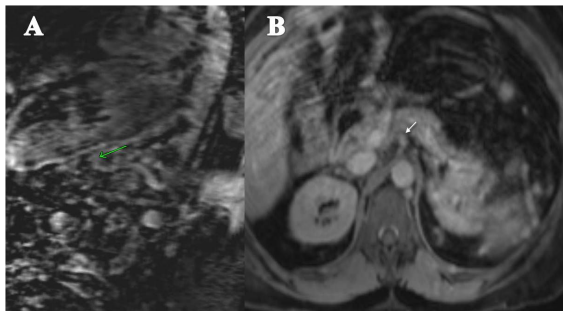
MRI & MRA reveal occlusion of the hepatic artery 2 cm from its origin and also evidence of collaterals.
